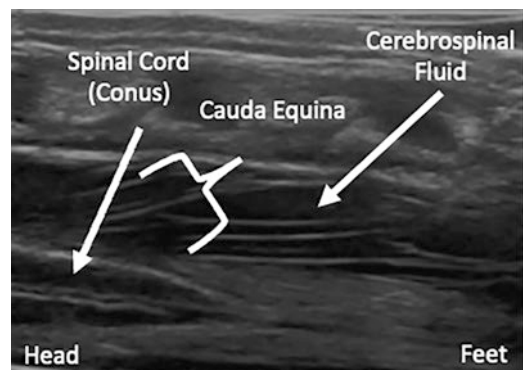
Ultrasound image of longitudinal view of basic spinal anatomy
